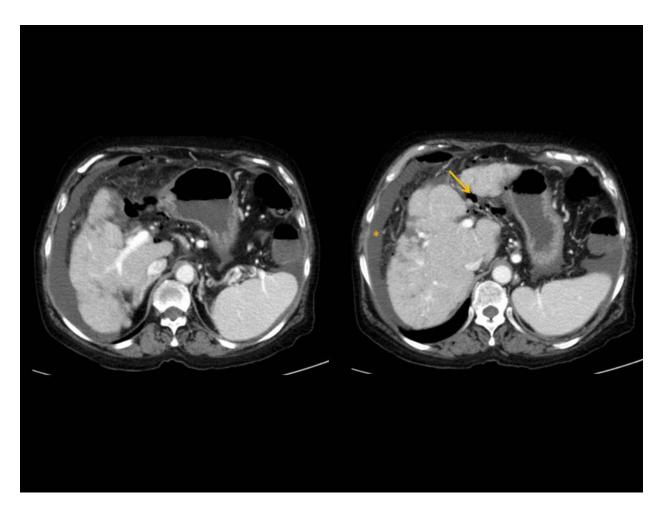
Axial CT images demonstrate a few locules of gas (arrow) seen in the hepatoduodenal ligament and the fissure for ligamentum venosum, which indicates a gastro/duodenal perforation. Note also the presence of peritoneal fluid (*) and stigmata of chronic hepatopathy. The patient went to surgery which confirmed a perforated duodenal ulcer.
